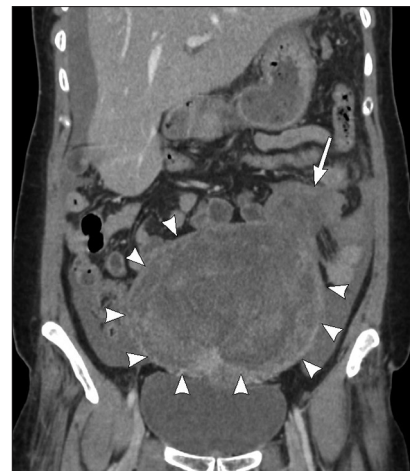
Post contrast axial computed tomography image showing a large heterogeneous pelvic mass “arrow heads” and high attenuation area inside it “arrow” suggesting active contrast extravasation
